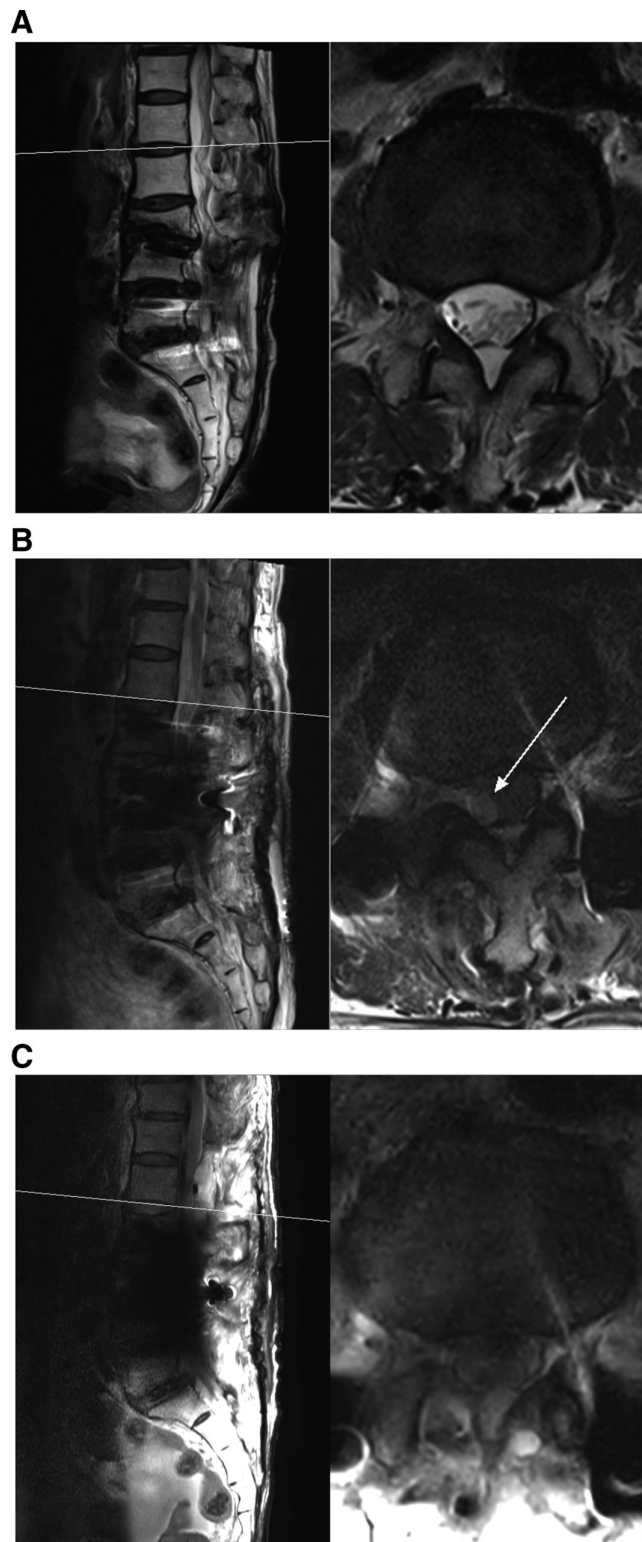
(A) Sagittal and axial T2-weighted MRI obtained preoperatively, 6 months after a previous laminectomy and discectomy at L4–5 and posterior lumbar interbody fusion at L4–5–S1. There were no signs of fluid collection. (B) Sagittal and axial T2 MRI obtained 10 days after the development of conus medullaris syndrome. The image reveals newly developed subdural complicated fluid collection (arrow) through the T12–L1–L2 level, which seems to cause moderate conus medullaris compromise. (C) Sagittal and axial T2 MRI obtained after hygroma evacuation. The previous fluid collection is resolved.
